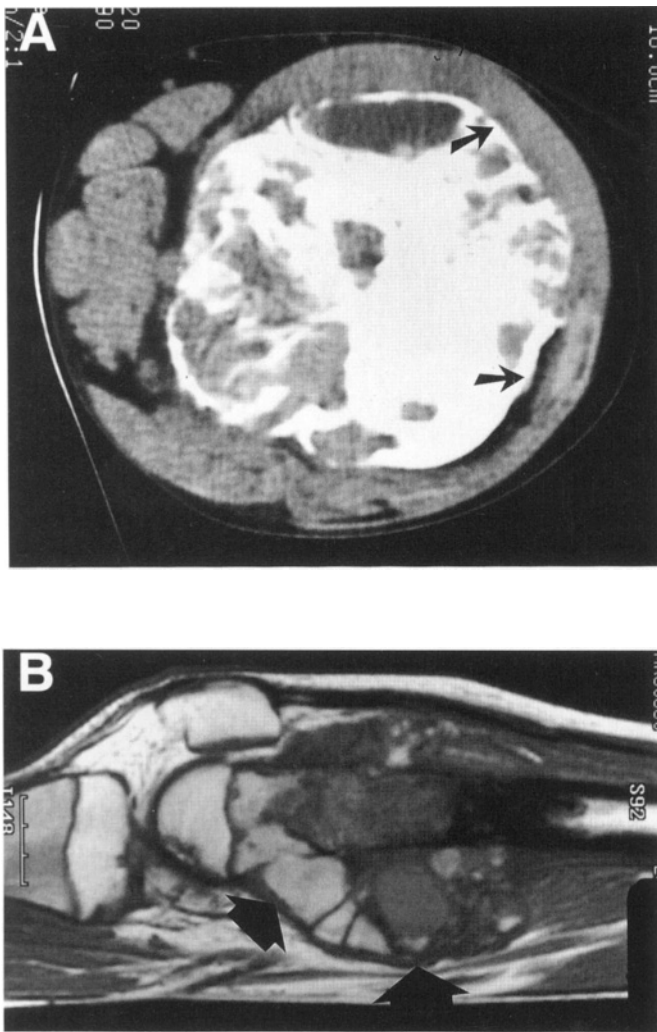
Typical radiographic response following induction chemotherapy. (A) CT scan of an extremely large tumor of the distal femur following induction chemotherapy. Note the complete sclerosis and rimming of the lesion (small arrows). A smooth rimming border is characteristic of a very high rate of tumor necrosis and an excellent chemotherapy effect. This patient underwent limb-sparing surgery with a distal femoral replacement in lieu of an initially planned high above-knee amputation. The amputation was initially considered due to the large size of the tumor. A vascular graft was not required. (B) MRI of the same patient shows a very typical black rimming response around the periphery of the tumor (solid arrows). MRI is not as reliable as CT in determining the response to chemotherapy. Although a solid black line around the periphery corresponds with the smooth cortical rimming seen on CT, this indicates the attempt of reossification and healing of the "tumor" defect.
